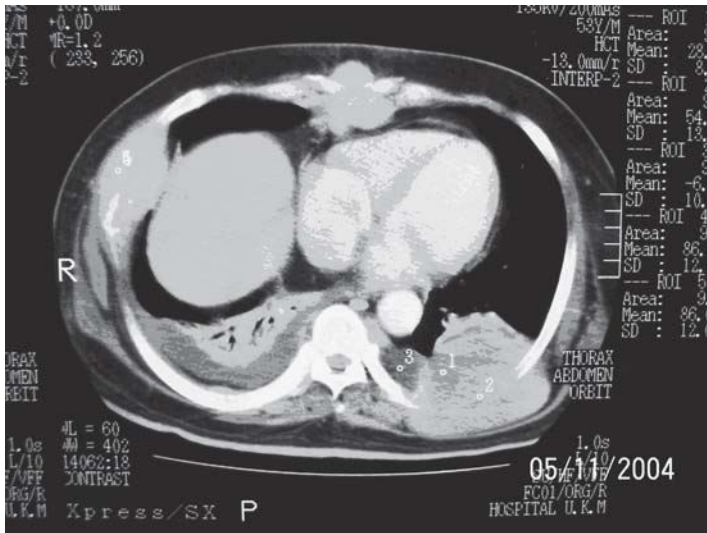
MRI showing huge mass at the left seventh rib
